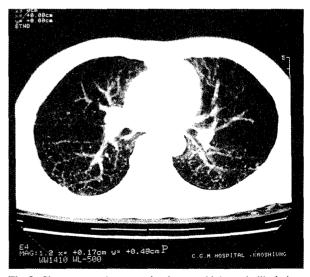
Chest computed tomography shows multiple cystic-like lesions permeating the entire lung parenchyma.
